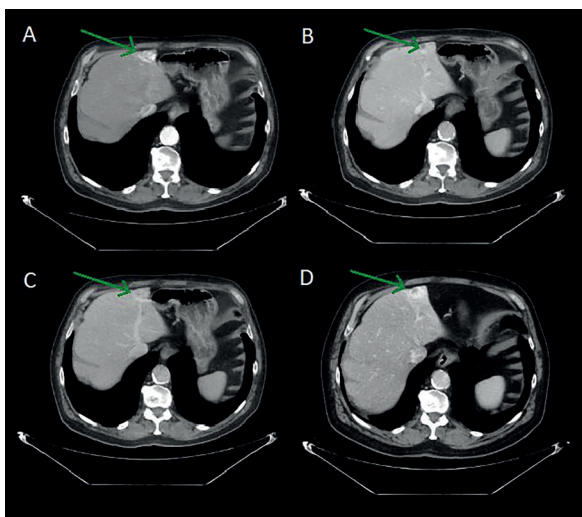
Abdominal contrast-enhanced computed tomography. In the liver, beneath the frontal capsule, there is an oval lesion that enhances after the administration of contrast medium intravenously. This enhancement is observed in the arterial phase (A), followed by a “wash out” in the portal (B) and venous phases (C). The lesion should be differentiated between a metastatic or primary liver tumor and an atypical hemangioma. A follow-up abdominal computed tomography (D) performed after 22 months revealed an oval lesion of the same size and enhancement pattern
